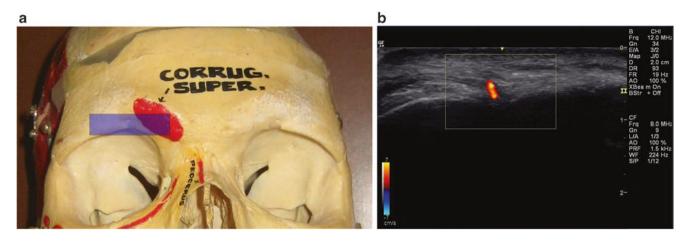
Scanning technique for supraorbital nerve injection (a) Transverse (axial) position of the transducer (semitransparent color rectangle), (b) Doppler mode identifying vessel
